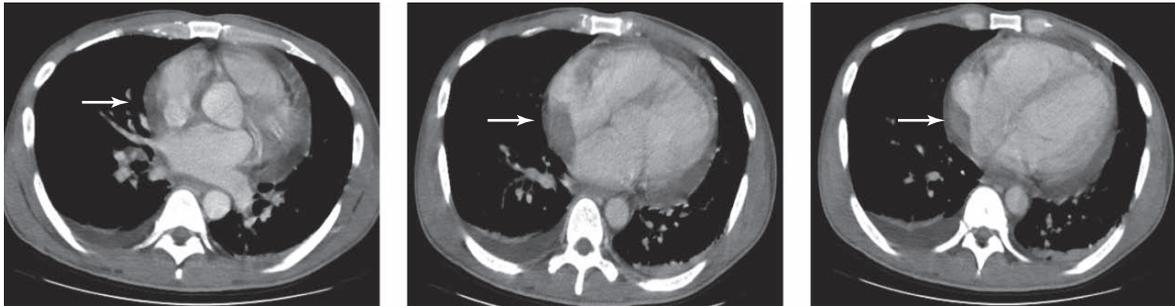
Contrast-enhanced computed tomography scan of the chest shows the presence of a filling defect in the right atrium measuring 5.0×3.0 cm. www.medreviews.com
